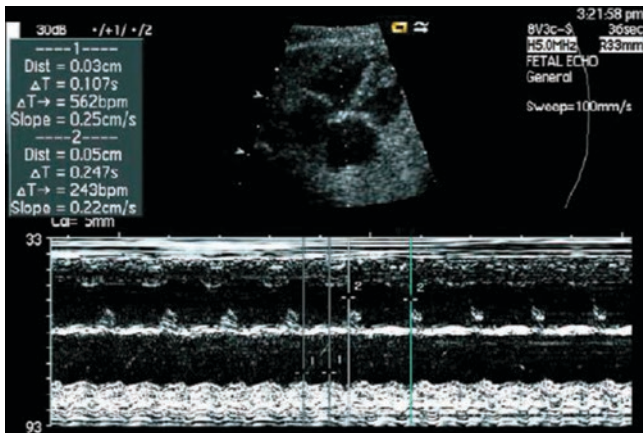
M-mode echocardiography of fetal atrial fibrillation, atrial rate > ventricular rate
